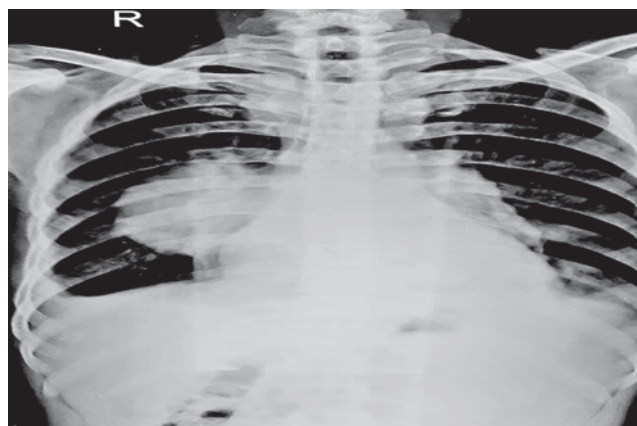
X-Ray of The Chest PA View
